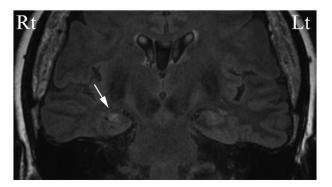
MRI FLAIR coronal section. Right hippocampal sclerosis is indicated by an arrow.
